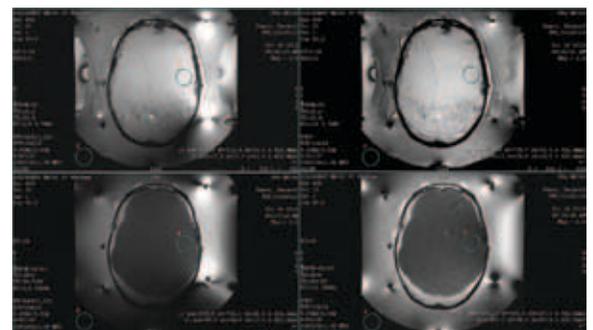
T2-weighted and TMAP MR images acquired with the body coil and prototype coil.
